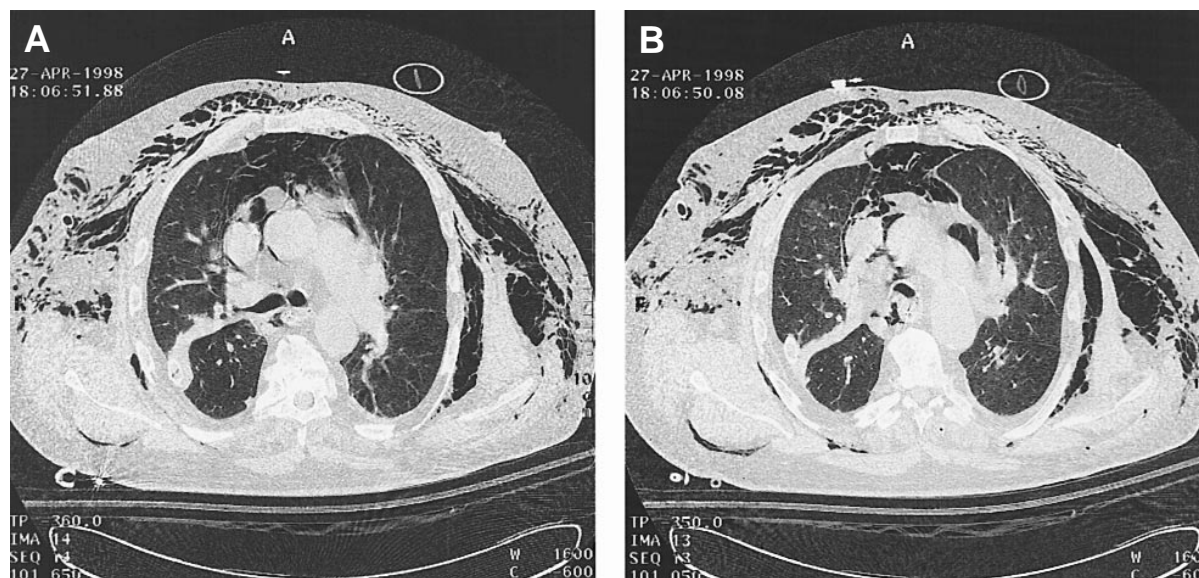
Chest computed tomography at the level of the main carina (A) and 10 mm upward (B), just at the level of the tracheal rupture.
